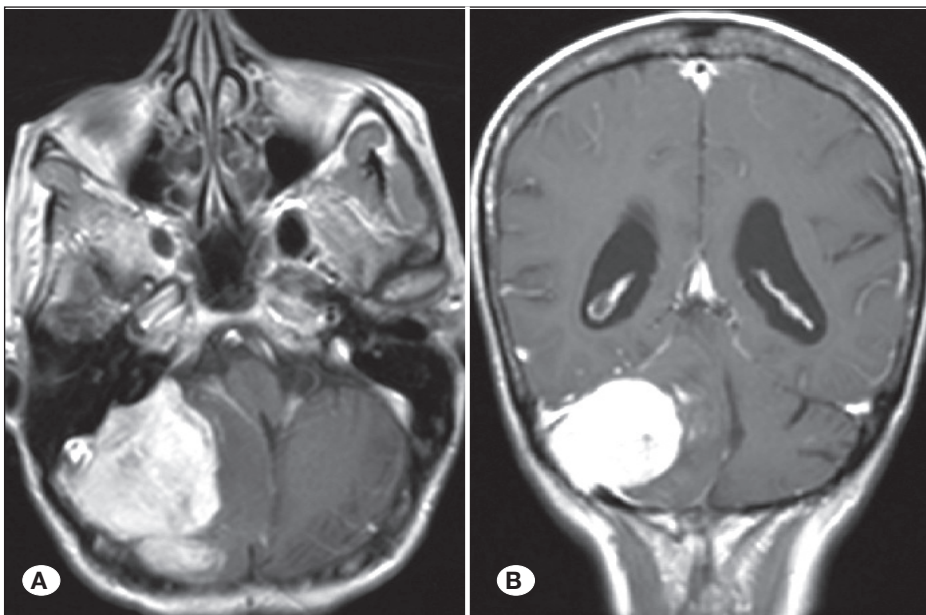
Preoperative magnetic resonance imaging. A) Preoperative axial T1-weighted fluid-attenuated inversion recovery (FLAIR) MRI showing a tumor in the right CPA measuring 5.5×7×3 cm. B) Preoperative coronal T1-weighted MRI. There are two compartments showing different contrast enhancements. The medial compartment lesion does not show contrast enhancement.
